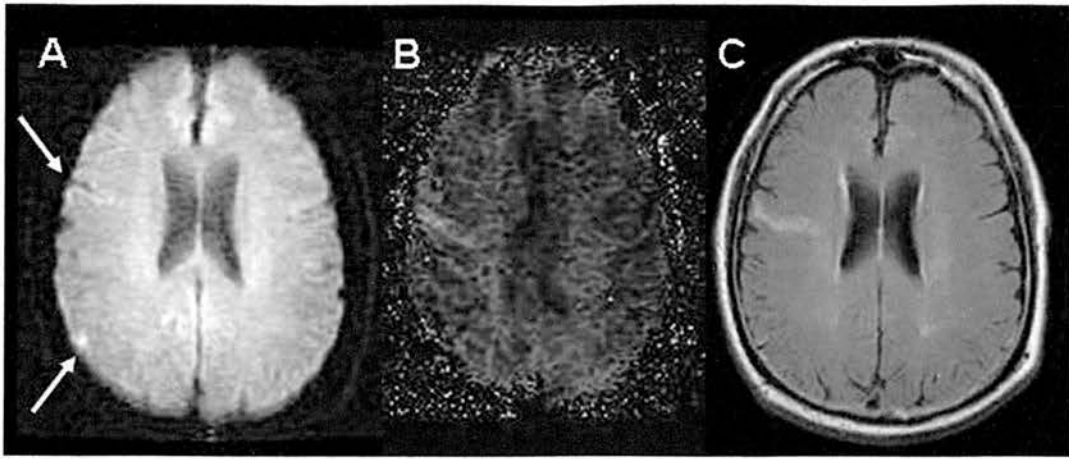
A. DWI lesions shown by arrows at baseline in a TIA patient whose symptoms of left sided weakness resolved within 30 minutes. B. shows the MTT abnormality at baseline. C. hyperintense region in right MCA territory on the FLAIR at 30 days. This is in the area of the abnormal perfusion abnormality at baseline. The patient was clinically asymptomatic.
